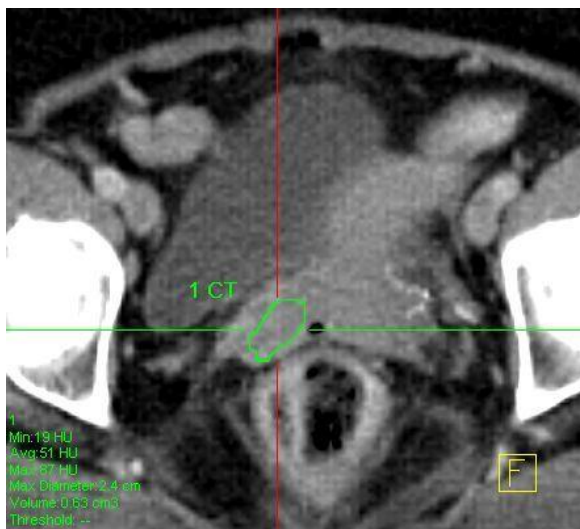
Axial CT image shows fairly normal vaginal soft tissue without discernible enhancing lesion. The 'hairline' marker indicates the site of the corroborated FDG-avid abnormality representing a tumour focus on PET/CT.
